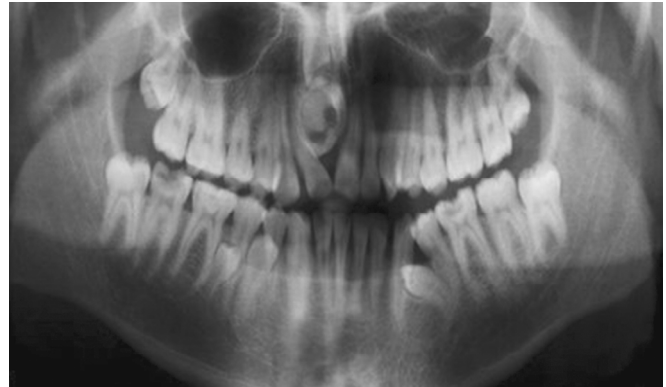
Radiographic picture of an impacted maxillary right central incisor and mandibular left first premolar
